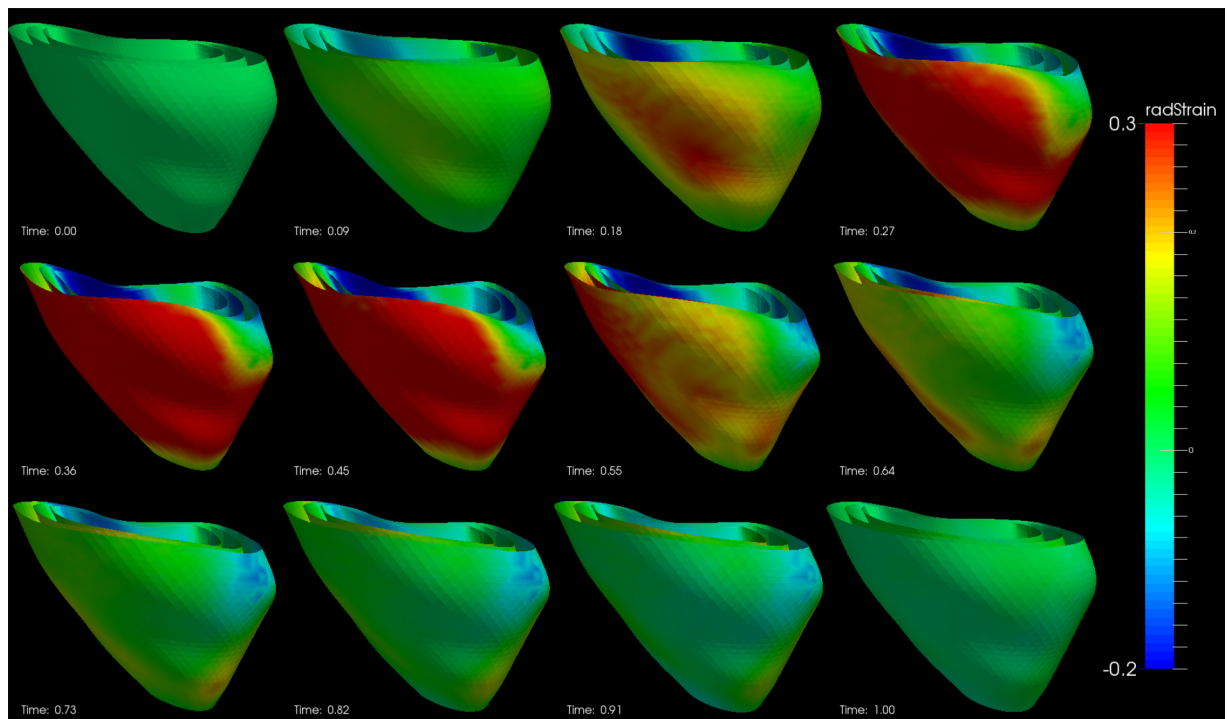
Radial strain of an example echocardiography sequence varying with time in a cardiac cycle. (The cardiac time is normalized between 0 and 1.)
